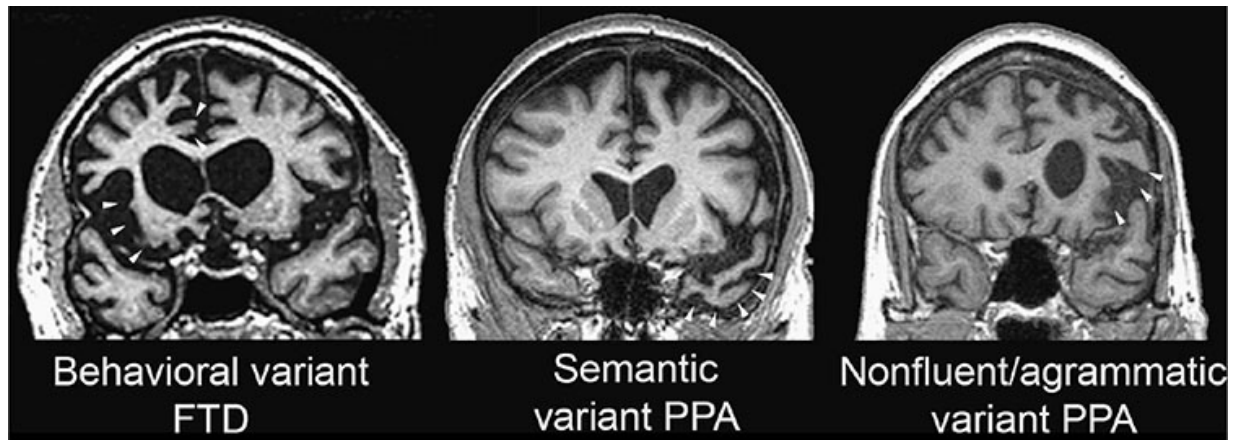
Three major frontotemporal dementia (FTD) clinical syndromes. Coronal MRI sections from representative patients with behavioral variant FTD (*left*) and the semantic (*center*) and nonfluent/agrammatic (*right*) variants of primary progressive aphasia (PPA). Areas of early and severe atrophy in each syndrome are highlighted (*white arrowheads*). The behavioral variant features anterior cingulate and frontoinsula atrophy, spreading to orbital and dorsolateral prefrontal cortex. Semantic variant PPA shows prominent temporopolar atrophy, more often on the left. Nonfluent/agrammatic variant PPA is associated with dominant frontal opercular and dorsal insula degeneration.
